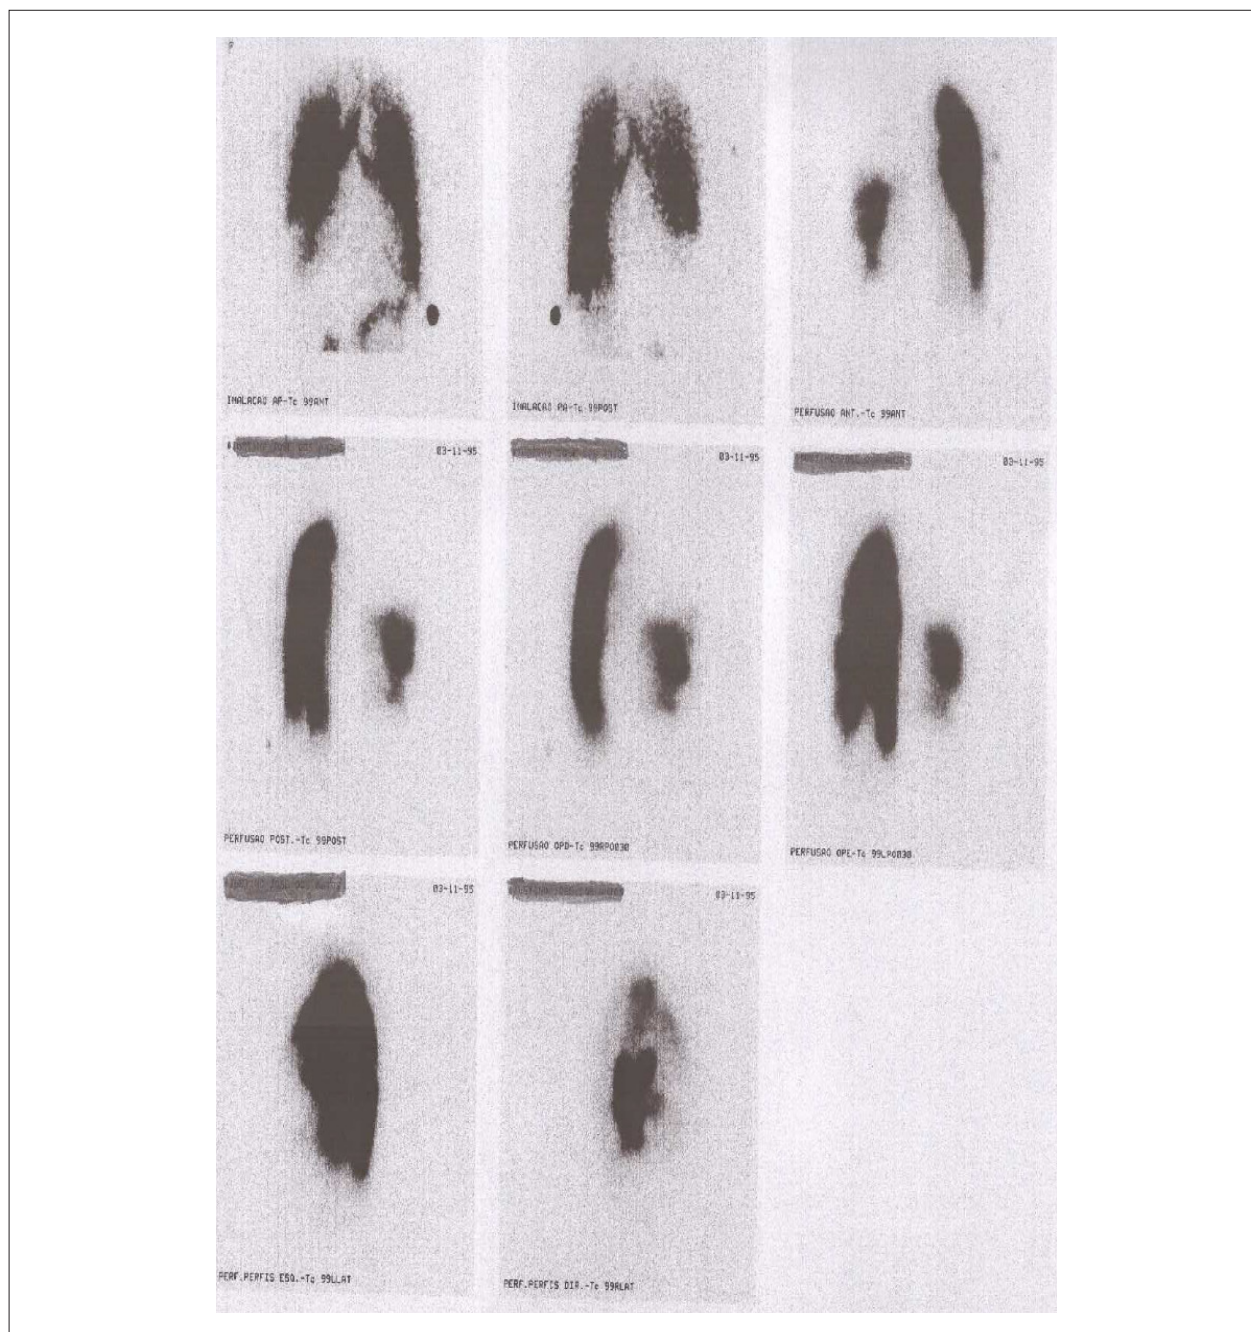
Pulmonary perfusion/ventilation scintigraphy showing hypoperfusion in the right upper lobe, anterior basal and lateral basal segments of the right lower lobe, lateral basal segment of the left lower lobe, and anterior segment of the left upper lobe, and decreased ventilation in the base of the right lung.
